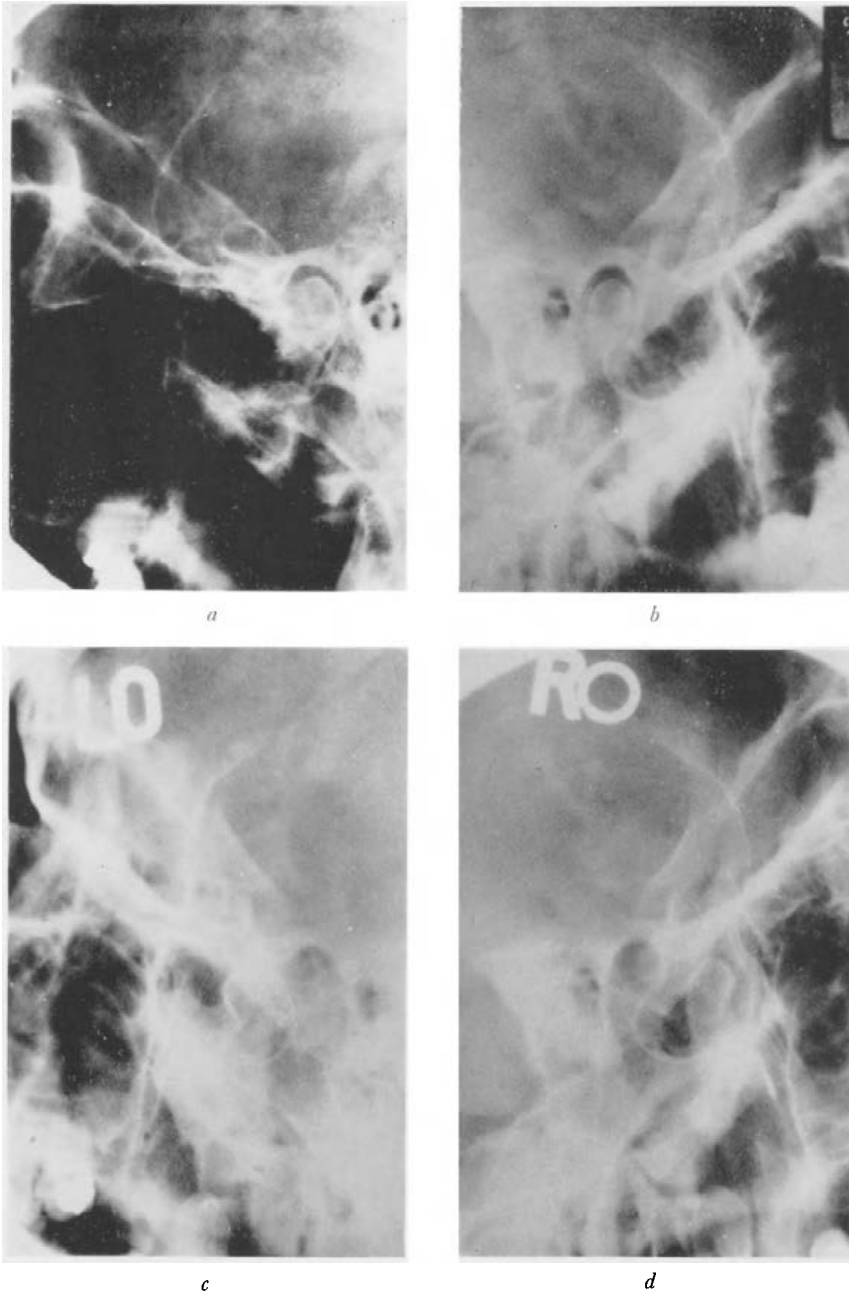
X-rays of condyles open and closed. Normal joint spaces at IP (*a* and *b*) and normal degrees of translation and rotation on opening (*c* and *d*). (By courtesy of Dr. J. J. Prior, Eastman Dental Hospital.)
